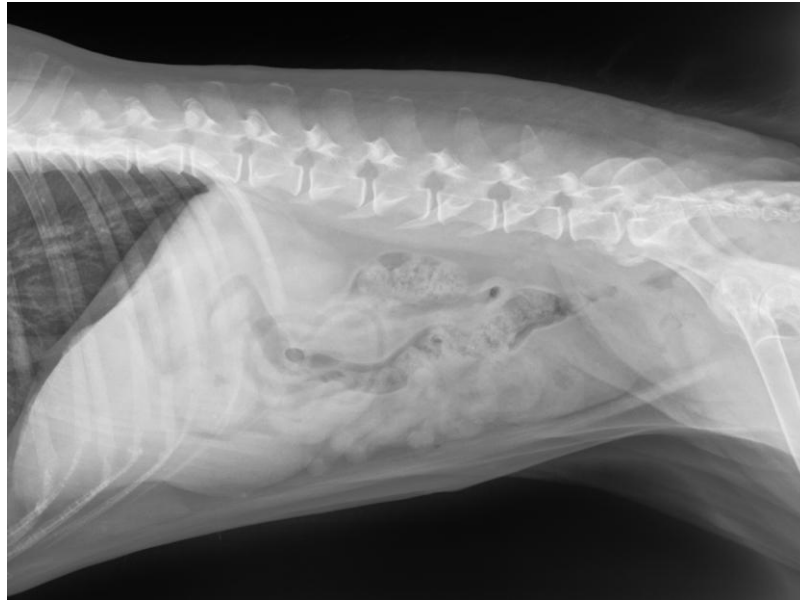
The right lateral abdominal radiograph revealed an irregular shape soft tissue density mass at the caudoventral abdomen that dorsally compressed the caudal descending colon. The architectural pattern of the mass was heterogeneous due to the small amount of radiolucent lesion. In addition, the sclerotic-bridging lesion was found at the ventral area of the lumbosacral joint.
